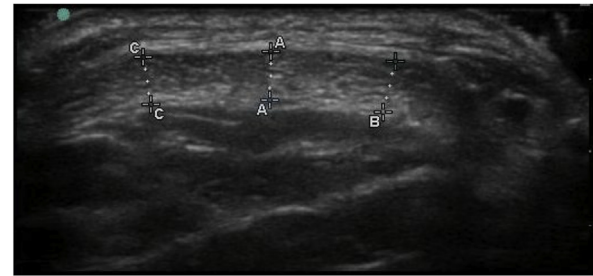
Sonographic image of measurement site (Transverse).
